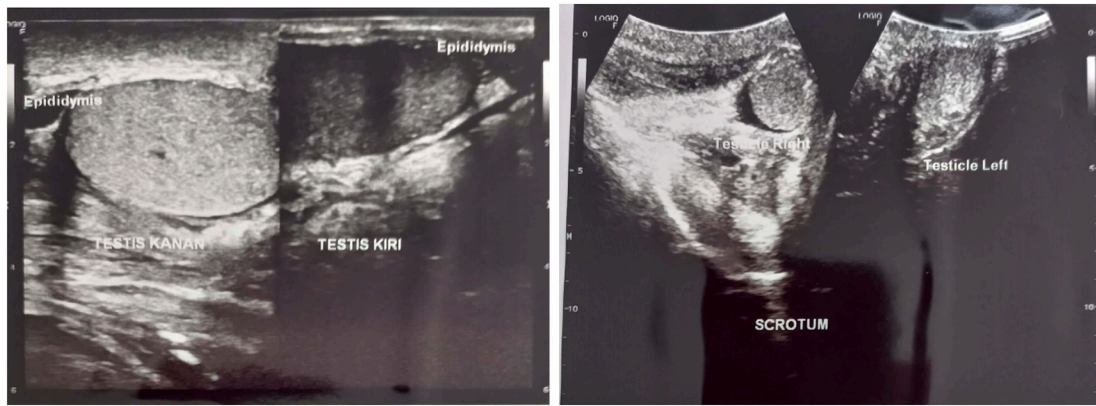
Ultrasonography evaluation of the testis.
